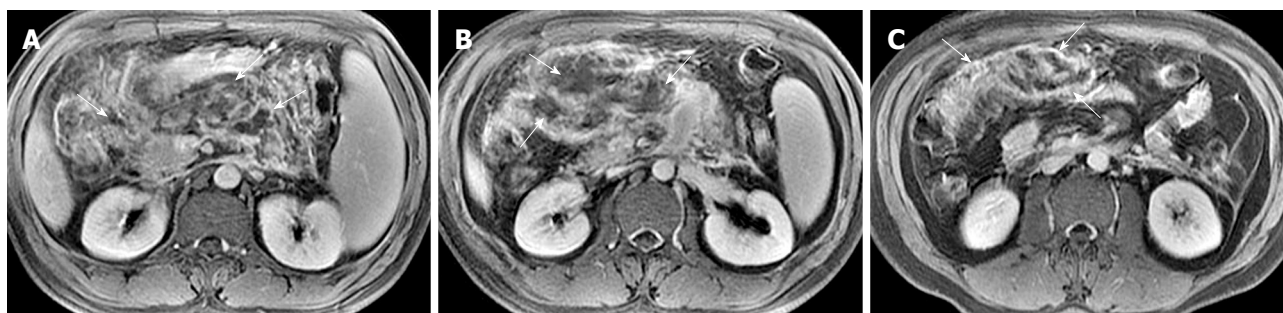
34-year-old man with acute pancreatitis. Contrast-enhanced axial T1-weighted images show peripancreatic inflammation extension (arrows) along the mesenteric adipose tissue region (A, B). There is addition irregular thickening and enhancement of the adjacent intestinal wall (arrows, C).
